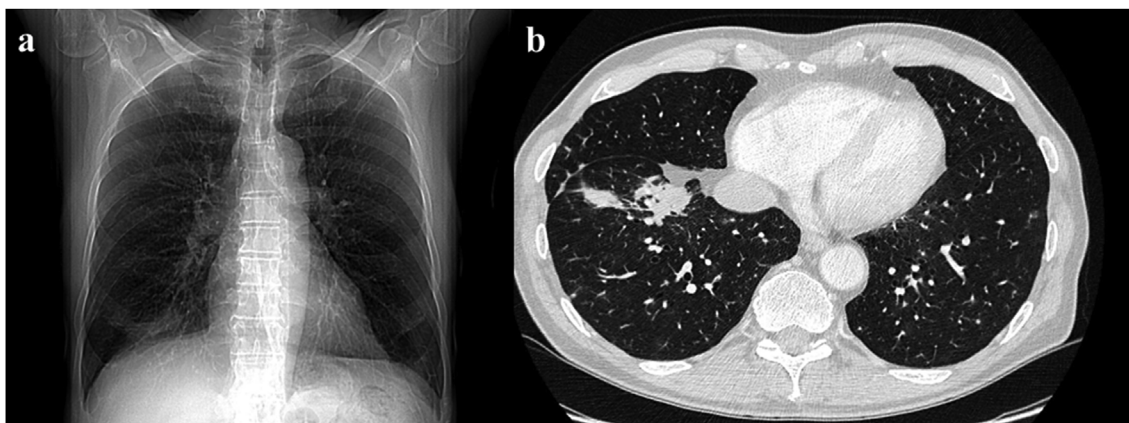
Posterior-anterior chest radiograph (a) and axial section of a CT scan (b) four years prior to diagnosis of disseminated coccidioidomycosis demonstrating consolidation in the lower right lobe.
